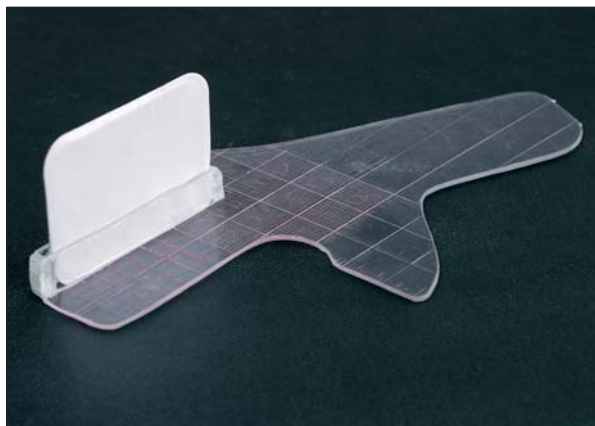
The film holder, which was fabricated by the investigators, consisted of the film backing, bite block, and indicating part. It was made of a transparent plastic. The straight side of the indicating part, which was perpendicular to the film backing, guided the projection of the x-ray beam. Several parallel lines were made on the bite block perpendicular to the film backing, which were used to ensure that the film holder was correctly positioned in the mouth.
